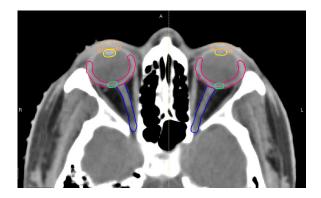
Anatomy of the eye via axial computed tomography scan. Orange = cornea, yellow = lens, pink = retina, green = macula, blue = optic nerve.
